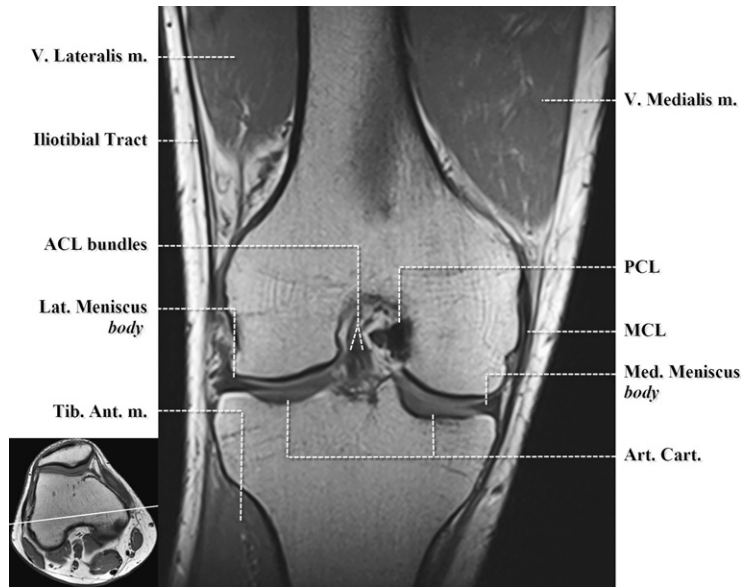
Coronal T1-weighted image. Mid coronal plane. ACL, anterior cruciate ligament; Art. Cart., articular cartilage; Med., medial; MCL, medial collateral ligament; m., muscle; Lat., lateral; PCL, posterior cruciate ligament; Tib. Ant., tibialis anterior; V., vastus.
